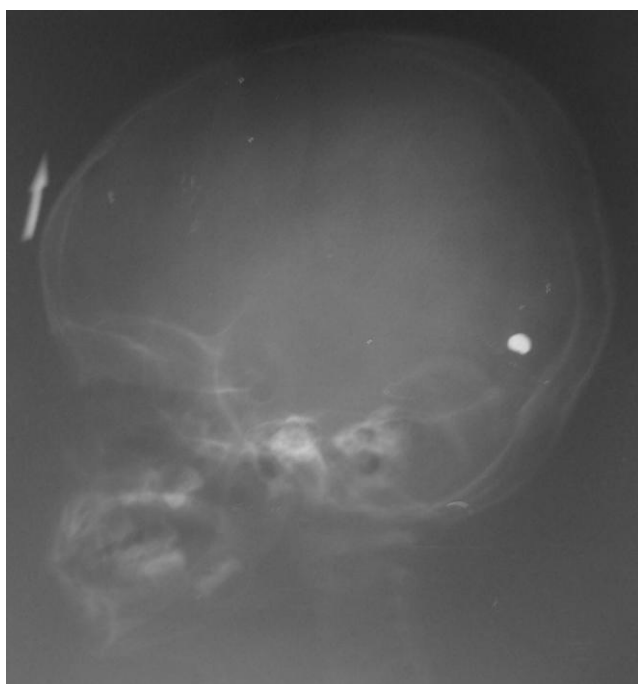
Skull radiograph lateral view; marker (arrow) and the pellet
